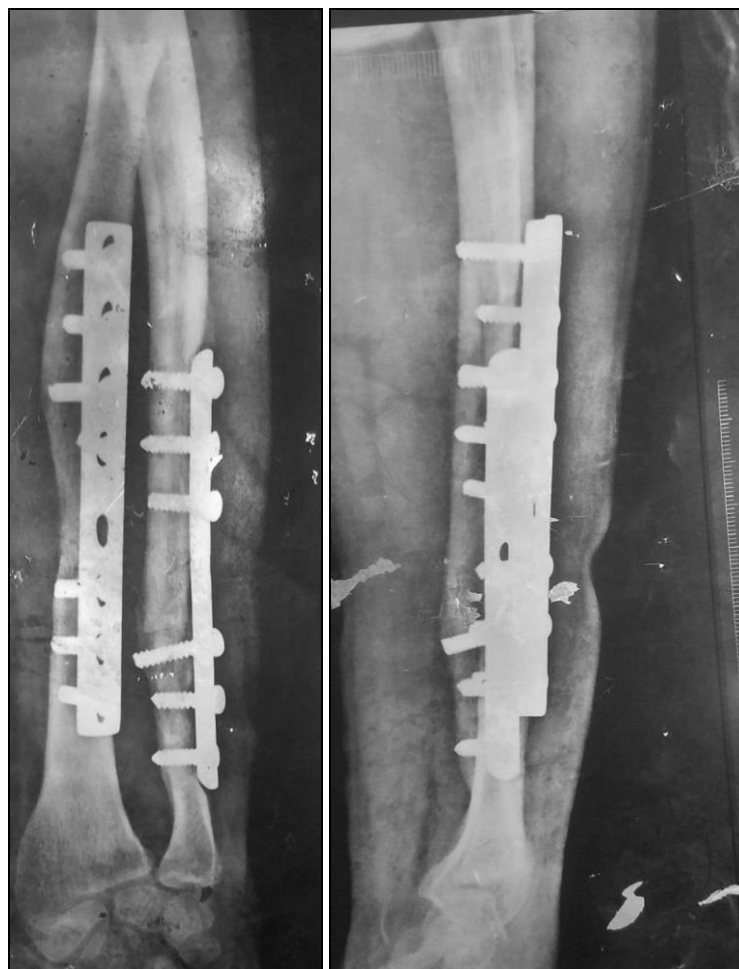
Anteroposterior and lateral view radiographs of another both bone forearm fracture.
